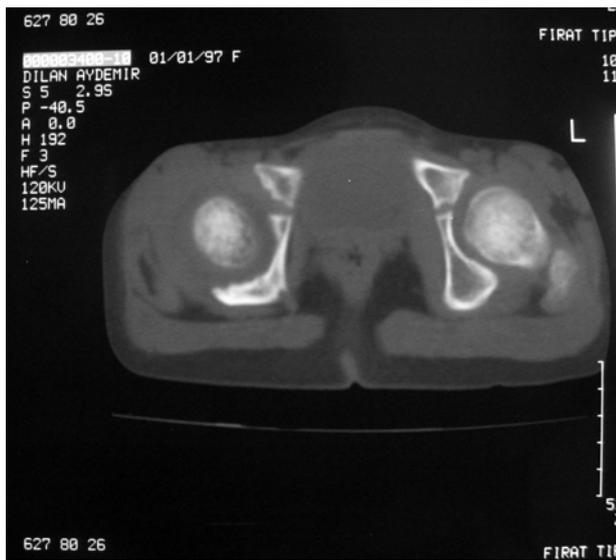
At the four-month follow-up visit, CT scan shows concentric reduction without dysplastic acetabulum. Thickness of the ischial part of the acetabulum is approximately same with the left side.
